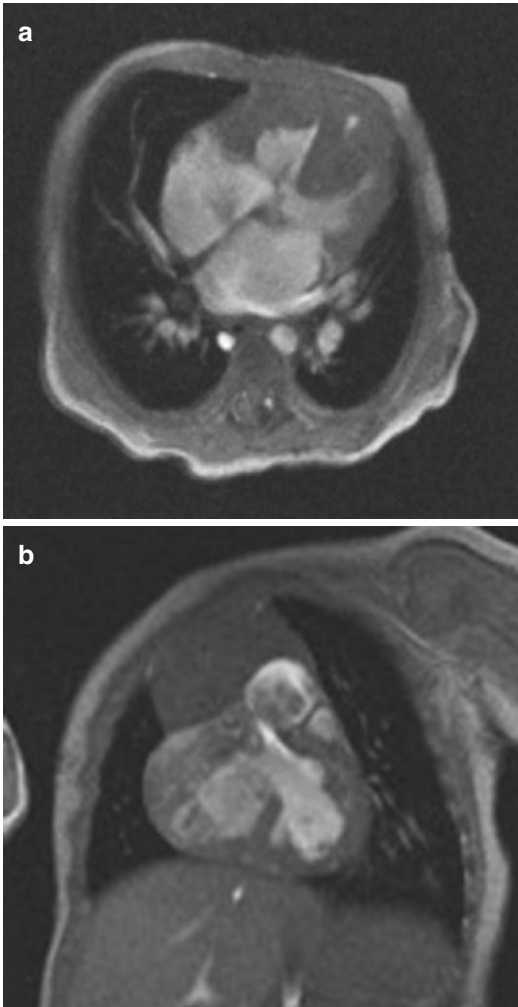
Perimembranous VSD. (a) Four-chamber view and (b) short-axis view cine FLASH MRI sequence images showing a perimembranous ventricular septal defect with inlet extension
